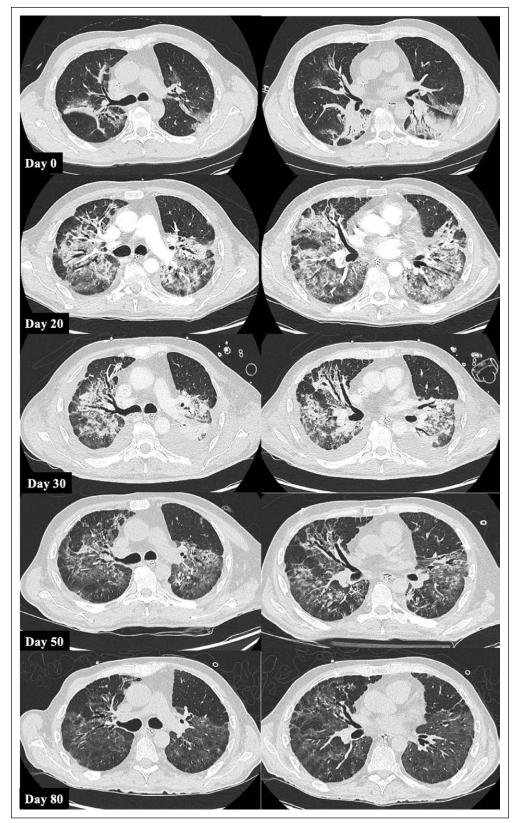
Time-course of chest CT from ICU admission to hospital discharge.
